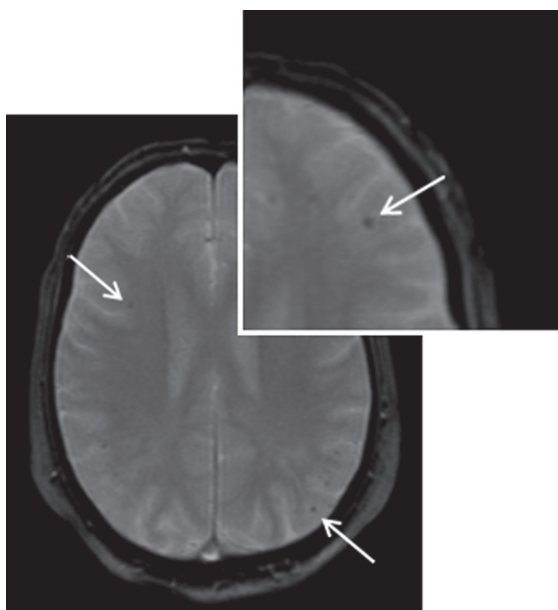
Baseline MR imaging of subject II.6. Cerebral MRI imaging of subject II.6 at age 70 showing several microbleeds (arrows). T2 weighted image.
